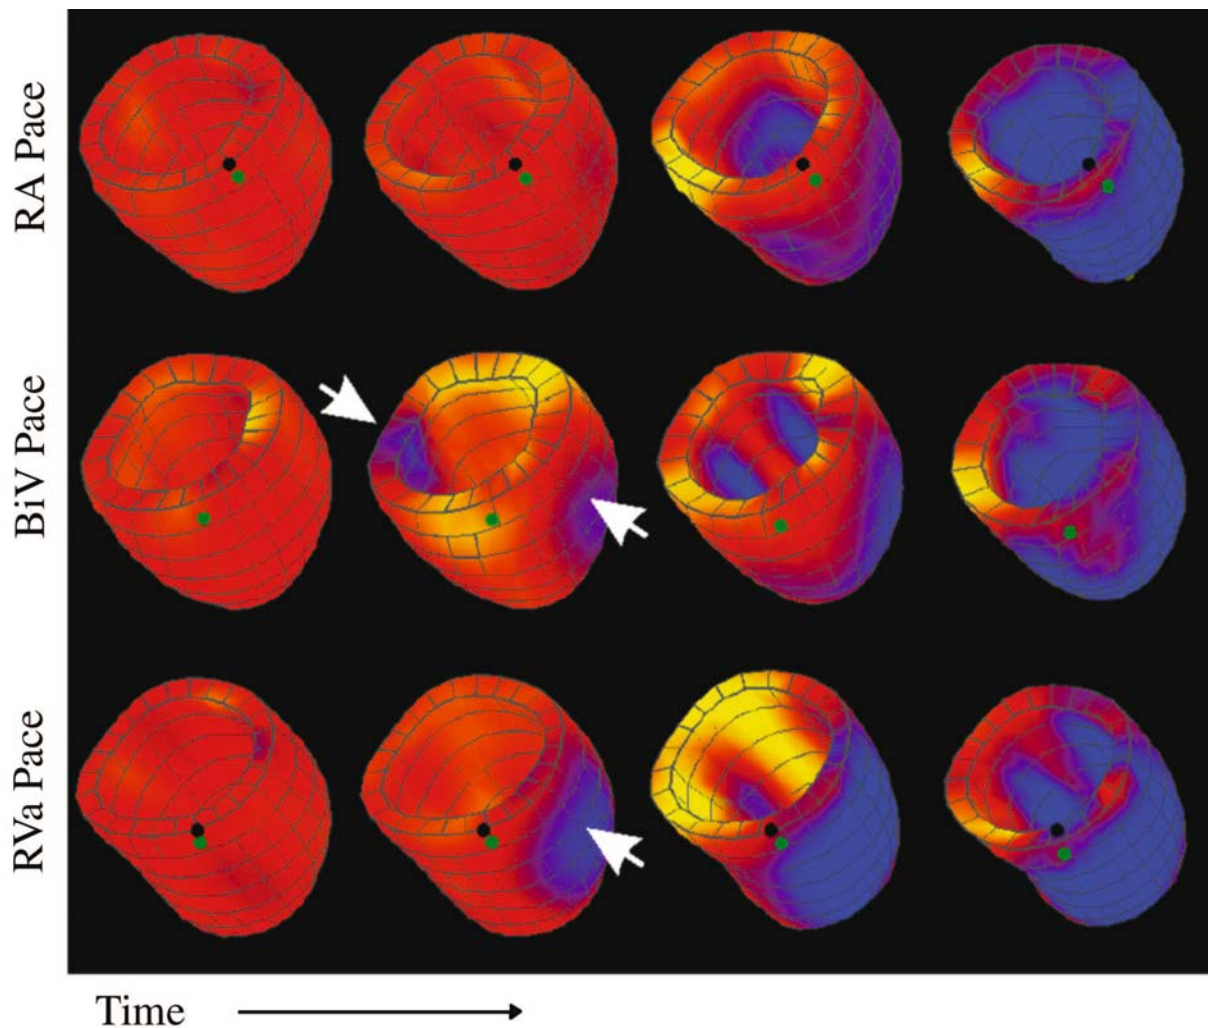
The temporal evolution of left ventricular shortening measured by magnetic resonance imaging tagging under different pacing protocols: right atrial pacing (top row), biventricular pacing (middle row), and right ventricular apex pacing (bottom row). Blue, contraction; red, reference state; yellow, stretch. Data are shown for late diastole after tagging (first column), early systole (second column), midsystole (third column), and late systole (last column). These measurements give precise quantification of the regional mechanical consequences of different pacing protocols. BiV, biventricular; RA, right atrial; RVa, right ventricular apex. Image provided by Dr. Eliot McVeigh (National Institutes of Health and Johns Hopkins Medical School). Further details about this study can be found in B.T. Wyman, W.C. Hunter, F.W. Prinzen, O.P. Faris, and E.R. McVeigh (2002), Effects of single- and biventricular pacing on temporal and spatial dynamics of ventricular contraction. *Am J Physiol Heart Circ Physiol.* 282, H372–H379.
